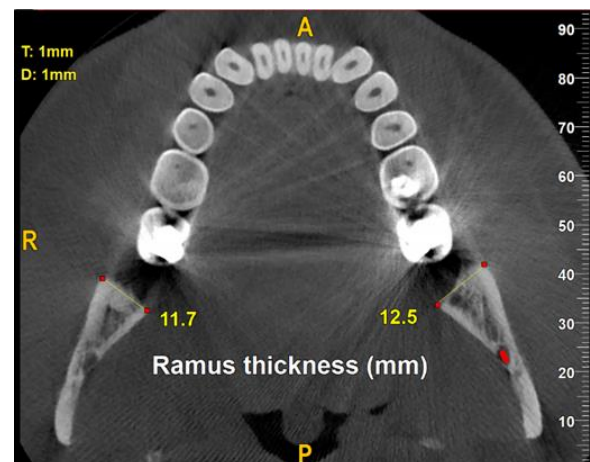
Measuring the ramus thickness on CBCT scans.
